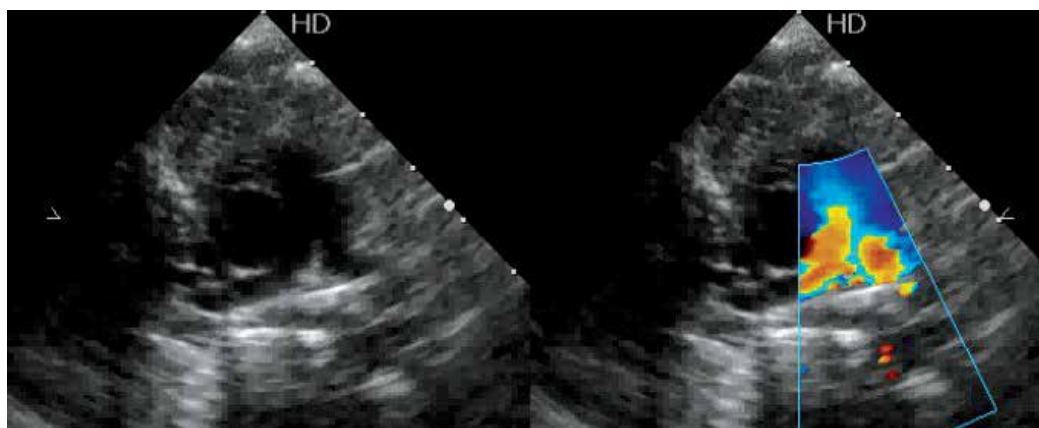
Echocardiographic parasternal short-axis image demonstrating a physiological peripheral pulmonary stenosis (yellow colour due to aliasing at the origin of both pulmonary arteries).
